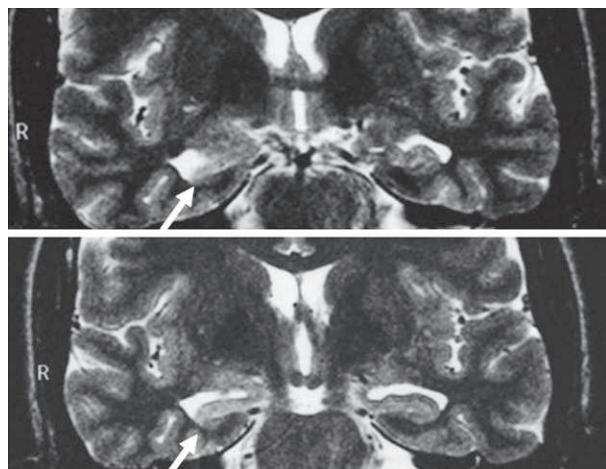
Coronal T2-weighted MR images in a 39 years old man from a family with MTLE. He had his first seizure at 17 years of age and a few other seizures during life. He has been seizure free without medication for several years. Observe the right hippocampal atrophy with hyperintense T2 signal and abnormal shape (arrows).
